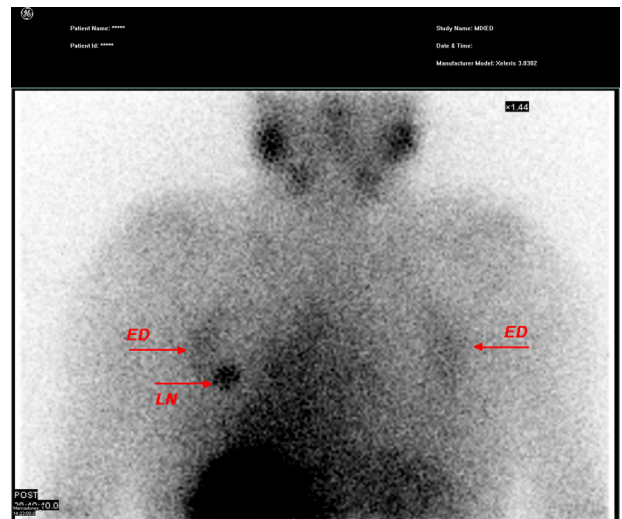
Posttherapy planar scan at 72 h post-dose showed a mild thoracic bilateral uptake in the posterior view probably coinciding with the elastofibroma dorsi diagnosed in previous CT (ED) as well as a moderate focal uptake localized in the left side of thoracic region which corresponded to the lung nodule (LN).
